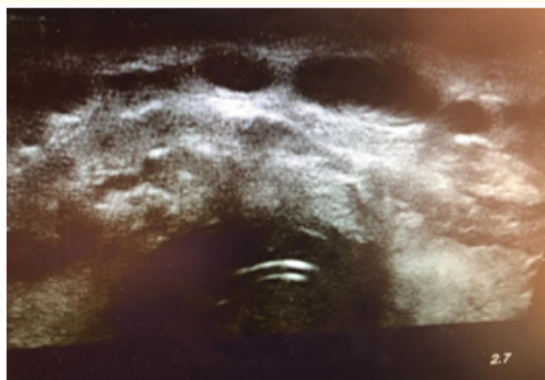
Ultrasonographic view of pretracheal region.
